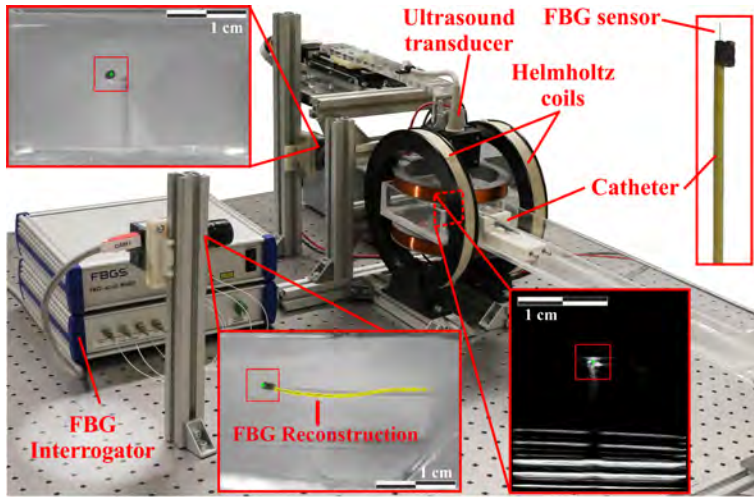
The magnetically-actuated flexible catheter setup: The magnetic field is generated by two pairs of Helmholtz coils. The flexible catheter has a stack of permanent magnets at its tip which are steered by the coils. The catheter tip is detected using 2D ultrasound images. The shape and tip pose of the catheter are also obtained using multi-core Fiber Bragg Grating sensors.
